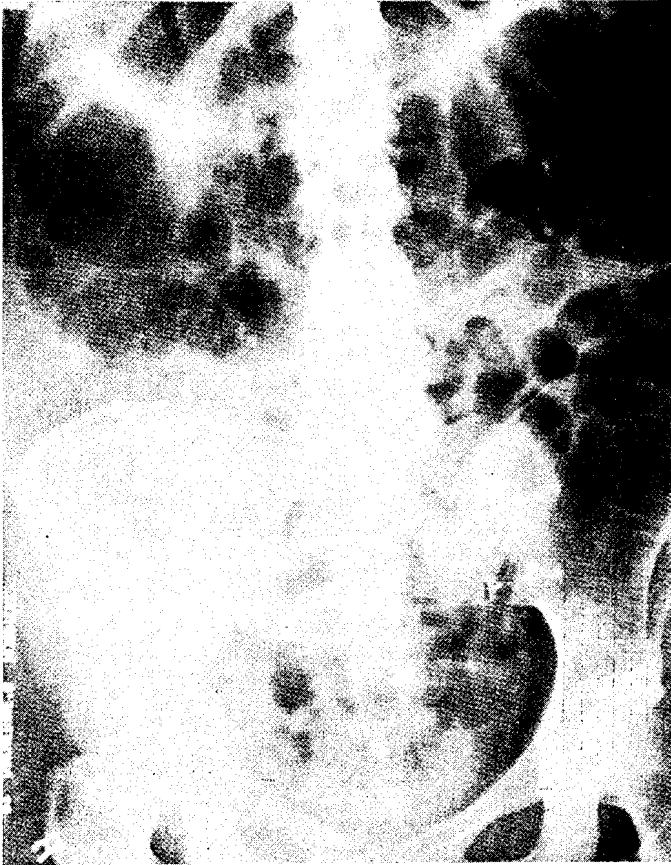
Case 42. Abdomen at time x-ray therapy was started.
